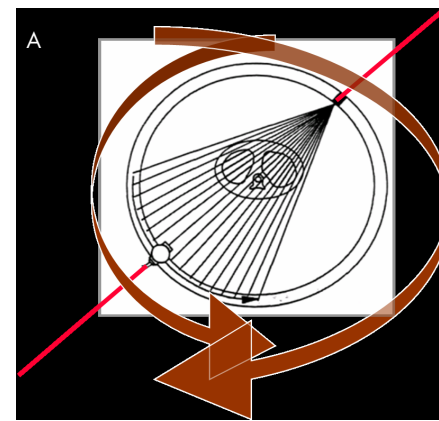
a,b,c. Beyond many years of studies performed by Conventional CT (a), the introduction of spiral CT allowed continuous data acquisition (b) and the consequent development of multislice CT allowed faster scanning by adding more rows of detectors (c)
